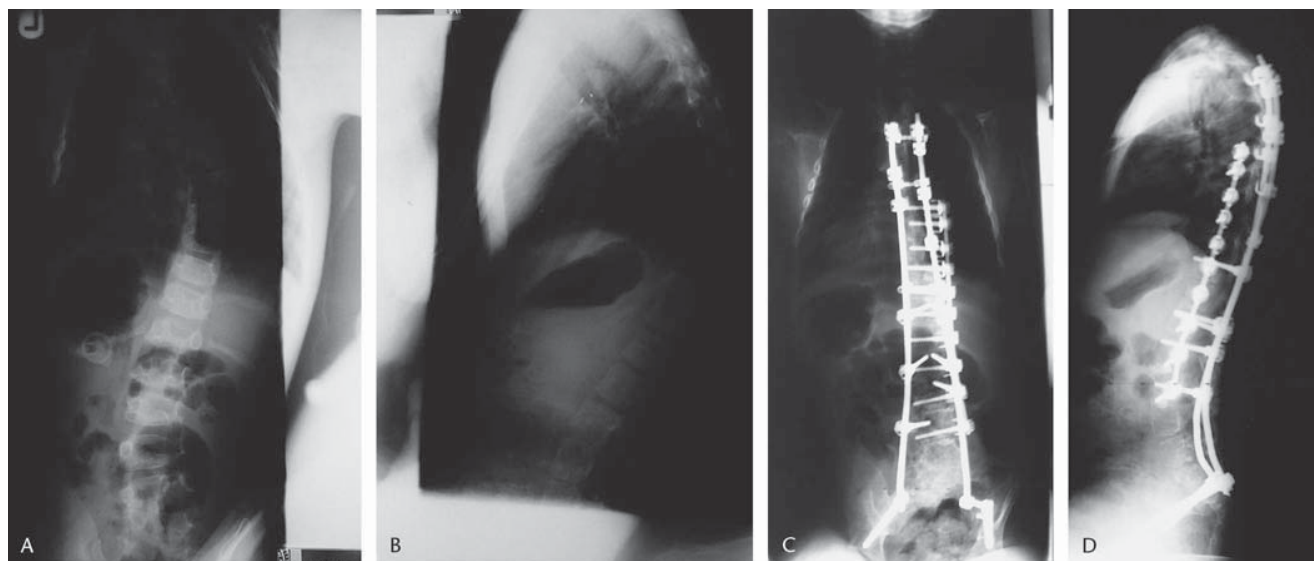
A–D, Posteroanterior, lateral preoperative, and follow-up radiographs following anteroposterior combined instrumented fusion in 12-year-old boy with spina bifida (see text).
